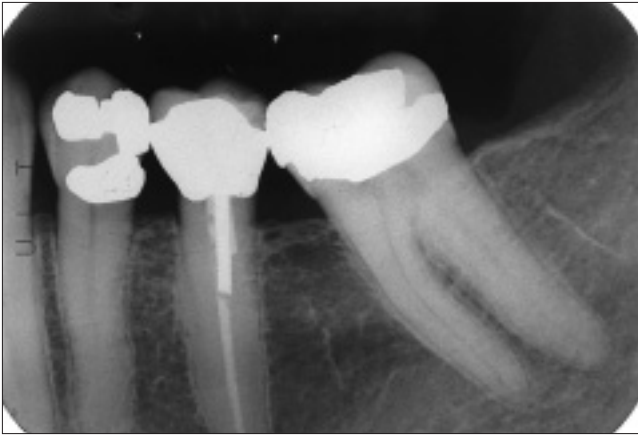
Preoperative radiograph of quadrant 3 before restorative or endodontic treatment.
